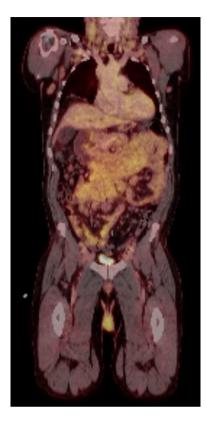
PET-CT showing bulky lymphadenopathy with the largest lymph node conglomerate being 8.4 × 15.6 × 16 cm. PET-CT, positron emission tomography-computed tomography.
